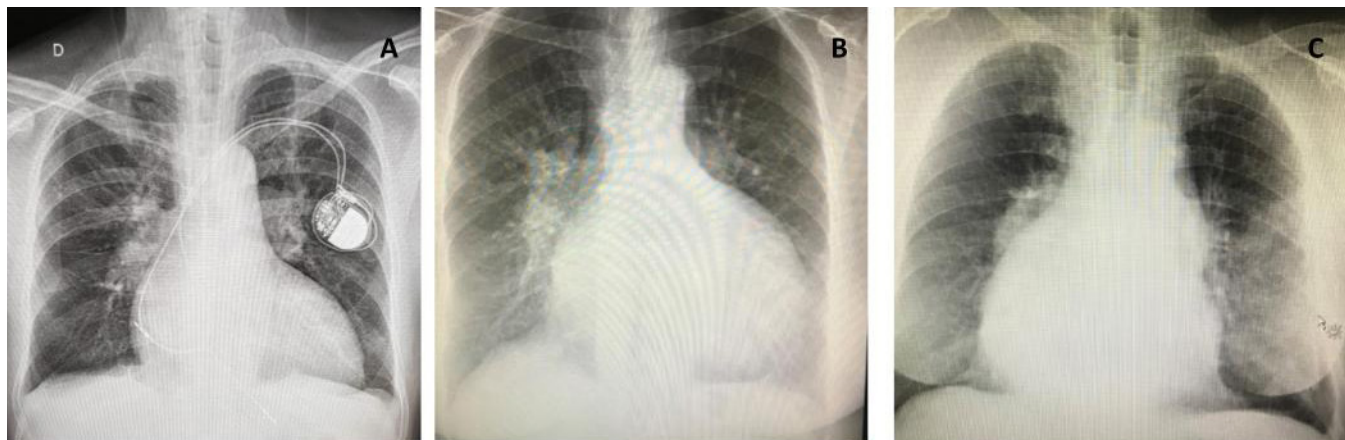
Chest radiographs of three patients with congenitally corrected transposition of the great arteries in heart failure. A) Deceased 70-year-old patient with tricuspid regurgitation (TR) + right ventricular (RV) dysfunction; B) 73-year-old patient with moderate TR/RV dysfunction (previous atrial septal defect closure) in NYHA class II; C) 69-year-old patient who refused surgery with large ventricular septal defect + severe pulmonary stenosis in NYHA class II (same patient of Figure 3B). NYHA=New York Heart Association.
